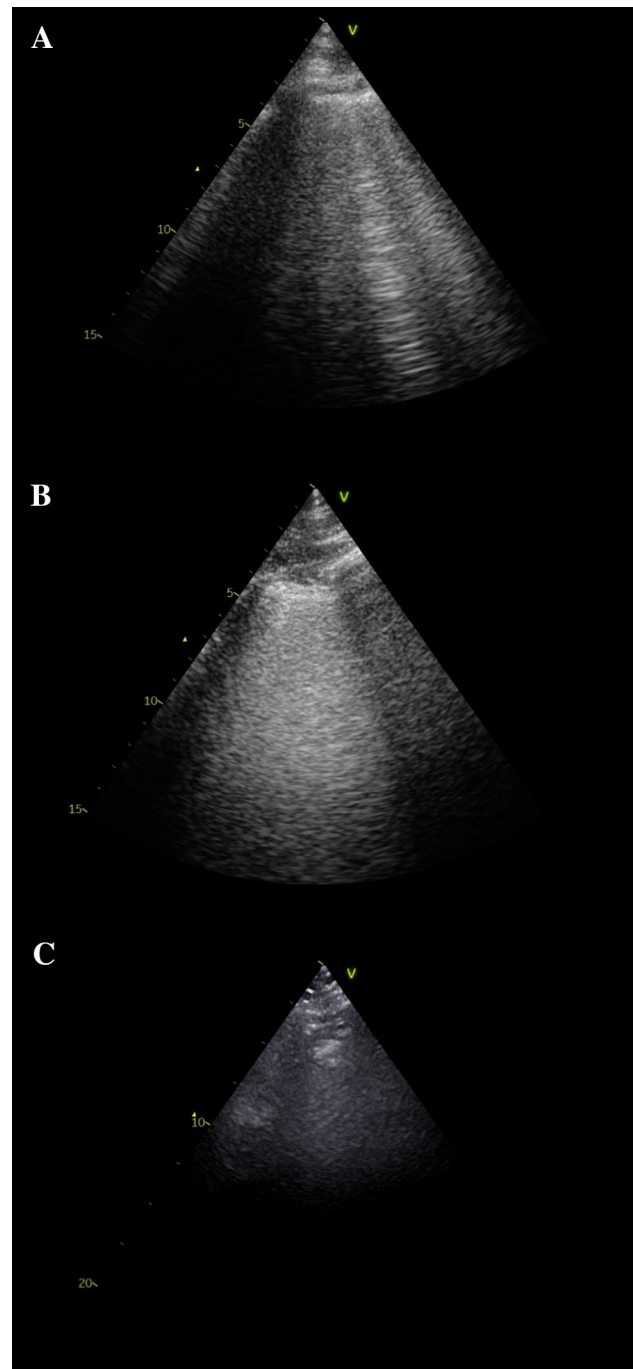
Pathological LUS findings. Examples of multiple B-lines (A), confluent B-lines and subpleural consolidations (B), and lobar consolidations (C) assessed with LUS. LUS lung ultrasonography
